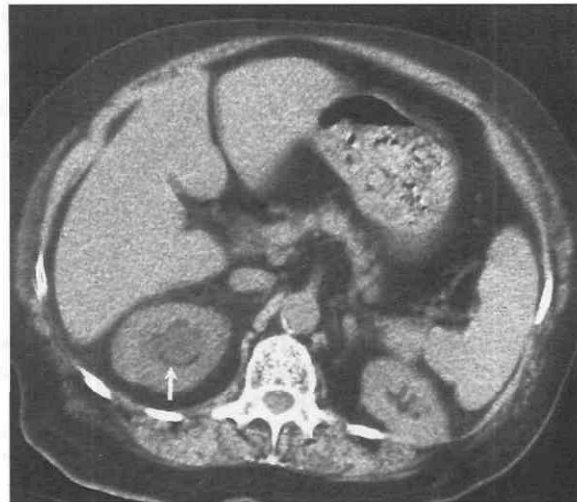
Non-contrast renal CT protocol. Axial image shows dilated calyx in the right renal upper pole (arrow) secondary to obstruction of the ureteropelvic junction (not shown).
